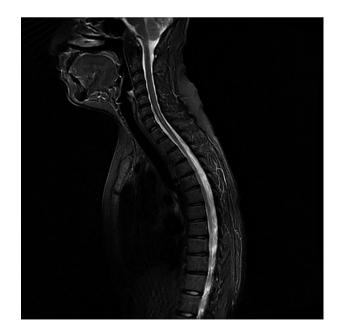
T_2 weighted MRI after treatment. MRI sagittal T_2 weighted image on day 252.
